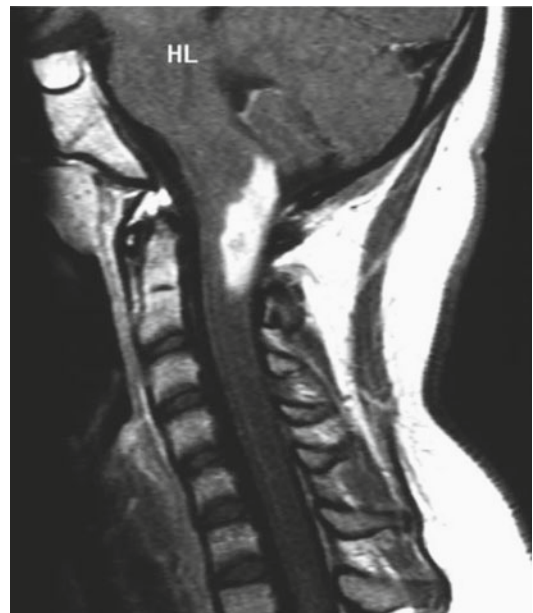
An unusual case of a ganglioglioma of the upper cervical spinal cord. The patient is a 14-year-old girl who presented with paresthesias over the left side of the neck. The sagittal T1-weighted post-contrast MRI shows a well-demarcated mass arising in the dorsal portion of the spinal cord
